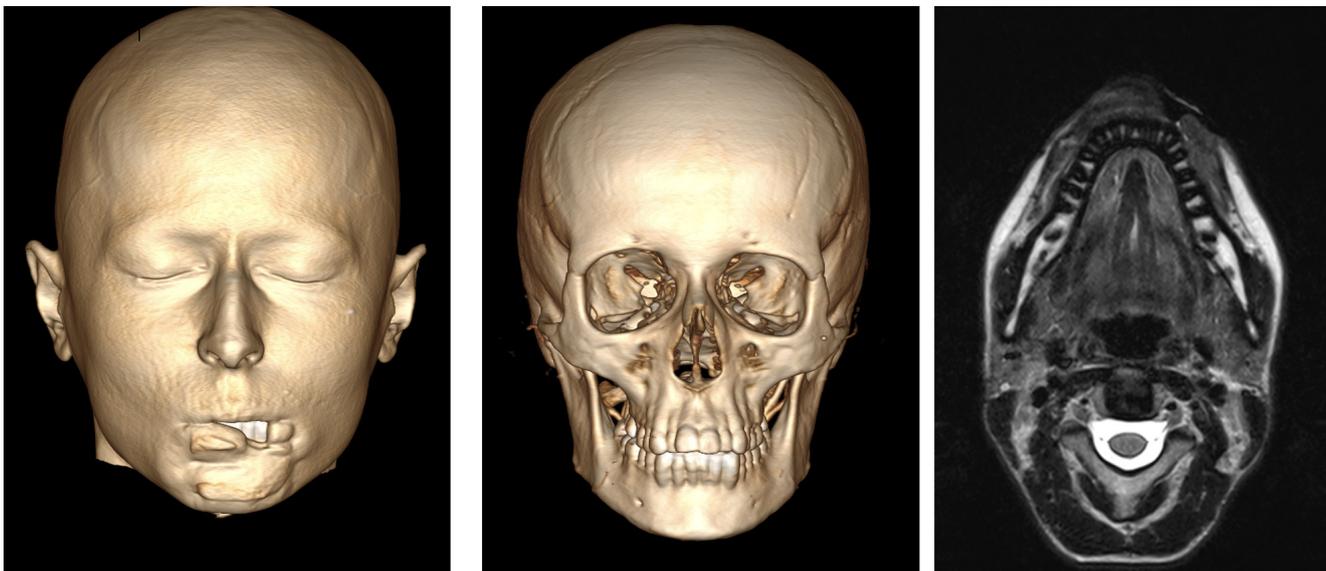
Contrast-enhanced MSCT and maxillofacial MRI before surgery: no foreign objects are visible in the defect area
